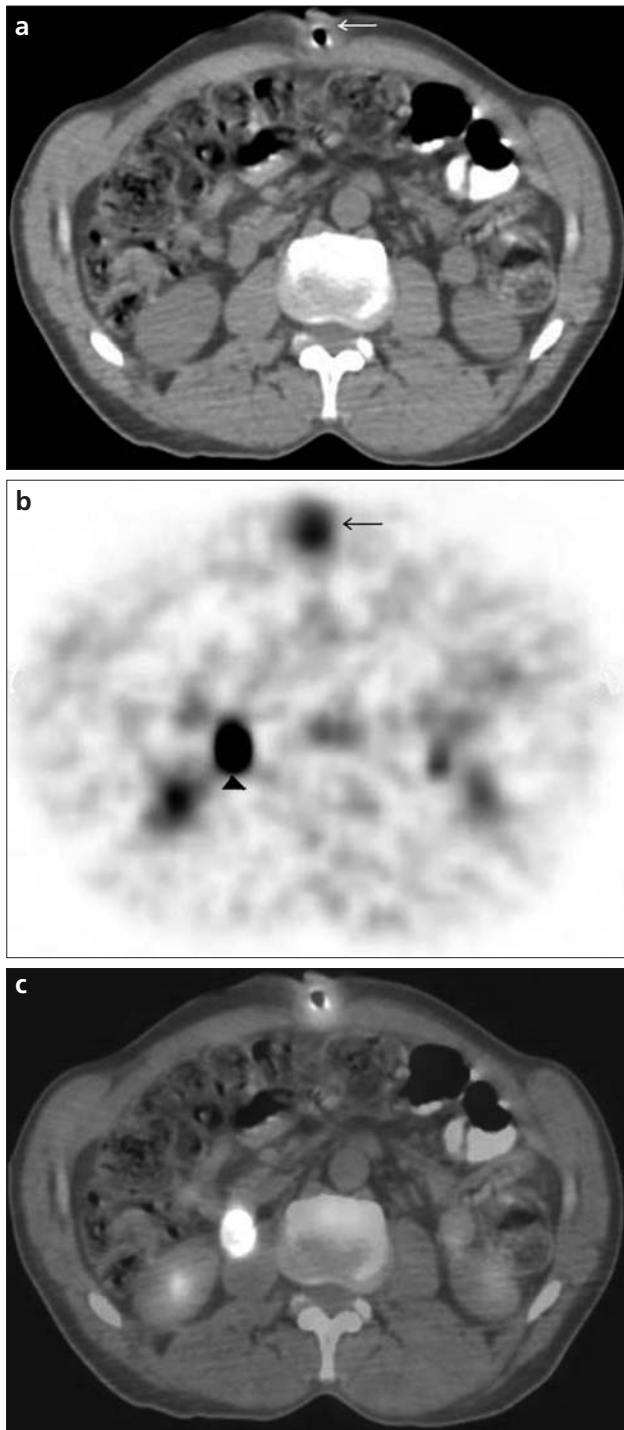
a-c. 72-year-old man operated for squamous cell carcinoma of the tongue had no symptoms related to the percutaneous endoscopic gastrostomy (PEG) site. Non-contrast-enhanced CT image (a) shows mild soft tissue thickening at the PEG site (arrow). PET image (b) shows mild uptake at the PEG site (arrow). Focal physiological uptake is seen in the right ureter (arrow head). Fusion PET-CT image (c). Biopsy from the soft tissue thickening showed granulation tissue.
